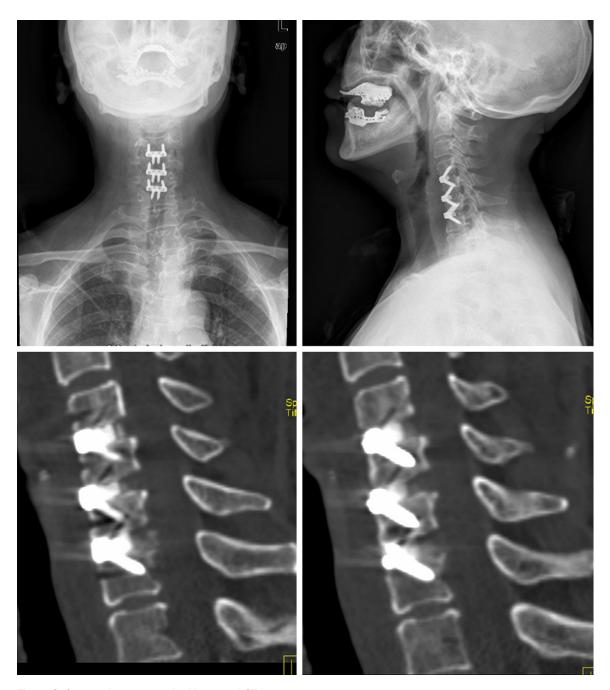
One week postoperative X-rays and CT scan.
